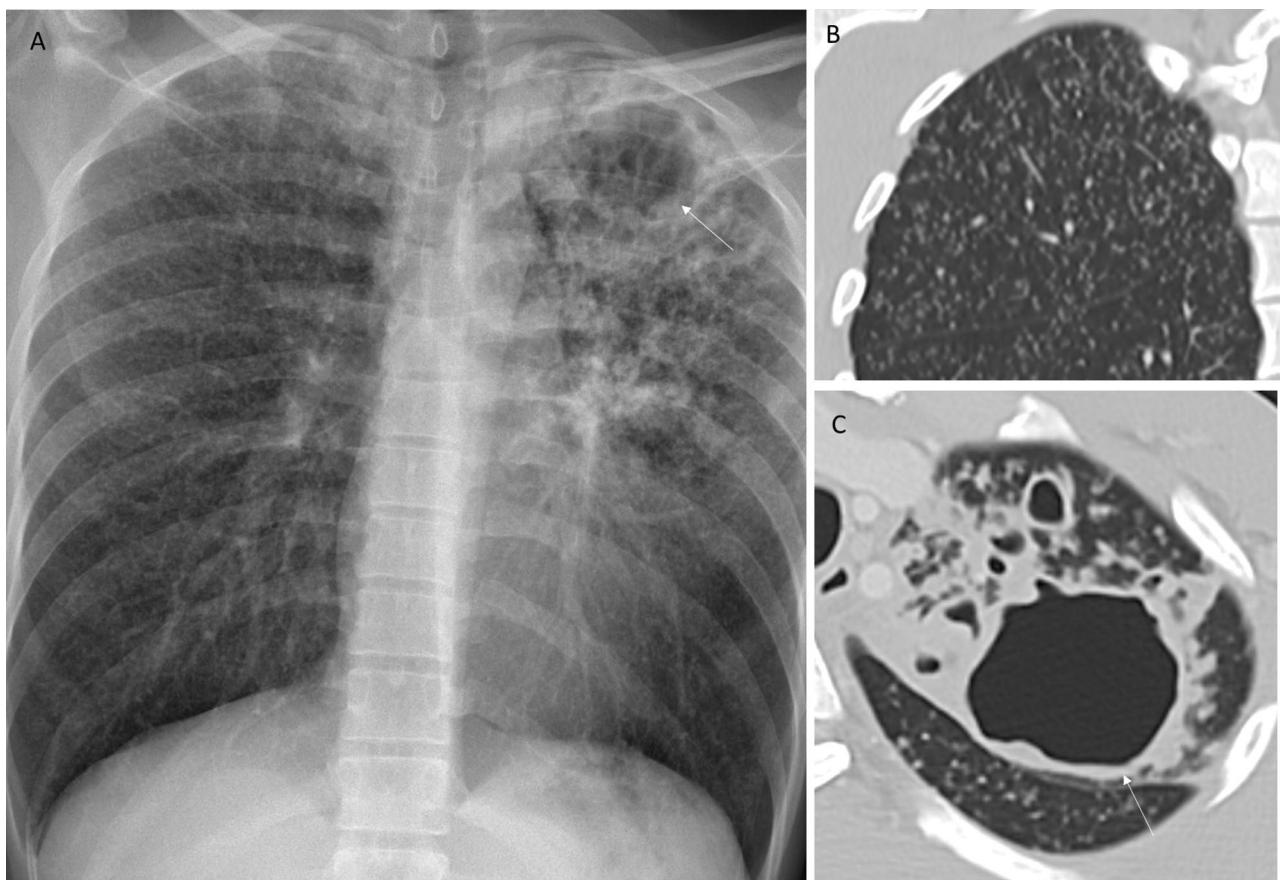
Chest X-ray (A), coronal CT image (B), and axial CT image (C) of a 25-year-old male with pulmonary tuberculosis. Multiple small nodules in random distribution, compatible with miliary tuberculosis, are depicted on X-ray (A) but in more detail on the CT image (B). The cavity (arrow) in the consolidation of the left upper lobe is detected on X-ray (A) but is better delineated on the CT image (C).
